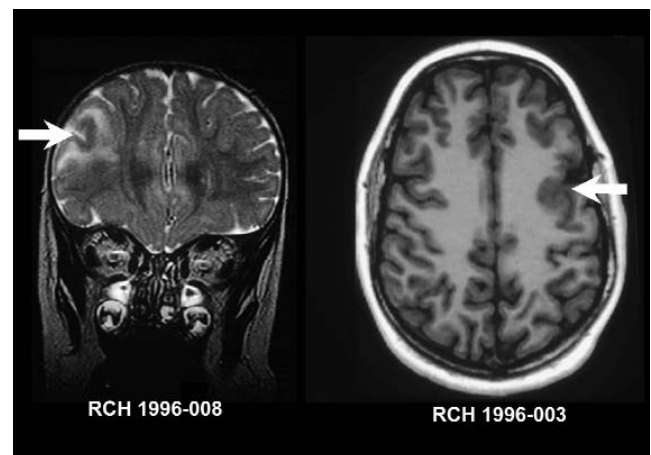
Imaging features of focal cortical dysplasia. Coronal T2-weighted MRI (left) and axial T1-weighted MRI (right) of two patients with focal cortical dysplasia. The image on the left shows area of gyral irregularity and increased subcortical signal (arrow) consistent with cortical dysplasia with signal change. The image on the right shows an area of unusual gyral formation and underlying thickening and blurring of the gray-white junction (arrow) consistent with cortical dysplasia without signal change. (No signal increase was seen on T2 weighted images.) MRI, magnetic resonance imaging
